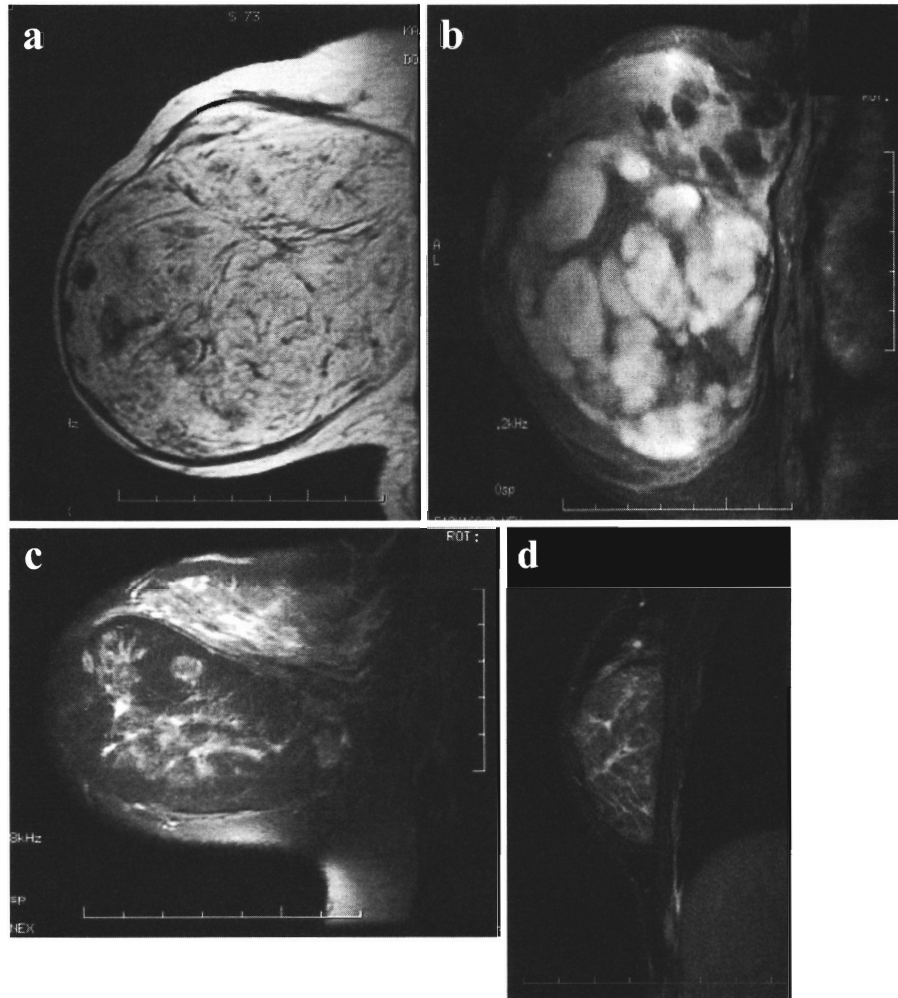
Mammary MRI findings
